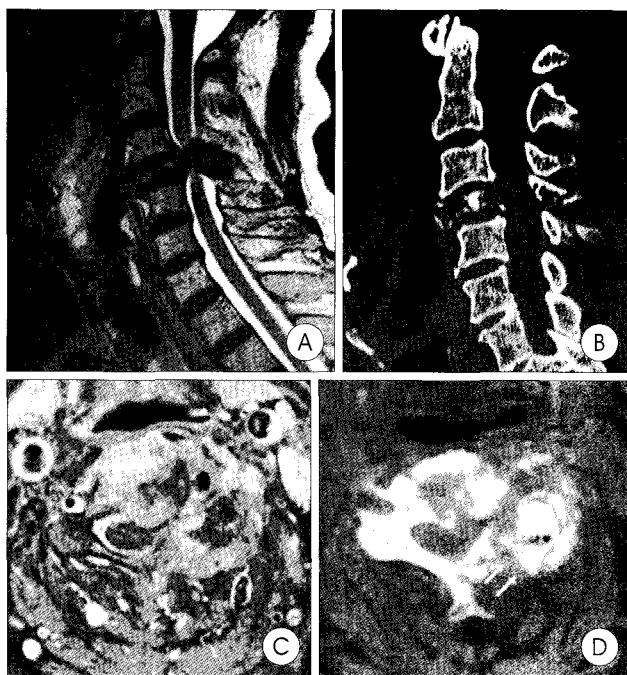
Preoperative magnetic resonance images and computerized tomography scans. (A, C) Sagittal T2-weighted image shows severe compression of the cord behind the C4 vertebra and axial T1-weighted image after gadolinium injection depicts the extent of the tumor mass destructing the whole C4 body, pedicle, facet joint and lamina of the left side. (B, D) Sagittal image shows collapse of C4 body and axial image reveals osteolytic lesions of left-sided pedicle, lamina, spinous process and especially, and fracture of lamina (white arrows). Note the coexisting involvement of both anterior and posterior elements of the vertebra by the lesion.
